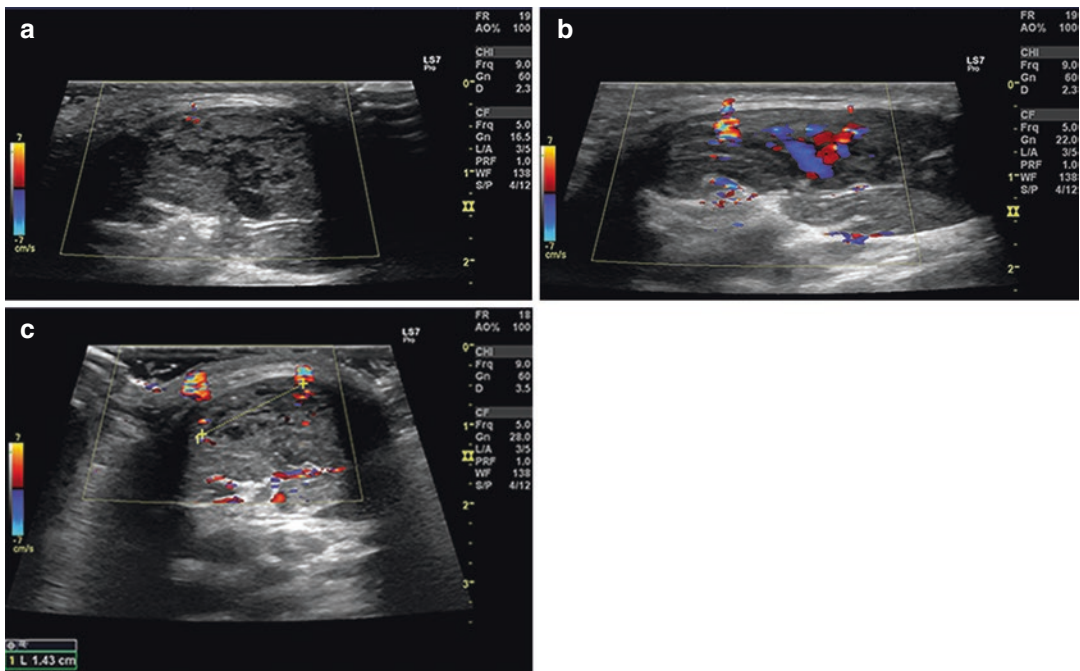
Muscular angiomyolipoma. Ultrasound aspects (a–c). Dishomogeneous echostructure formation (vascular, adipose, and muscular components) showing marked vascularization in Doppler colour
